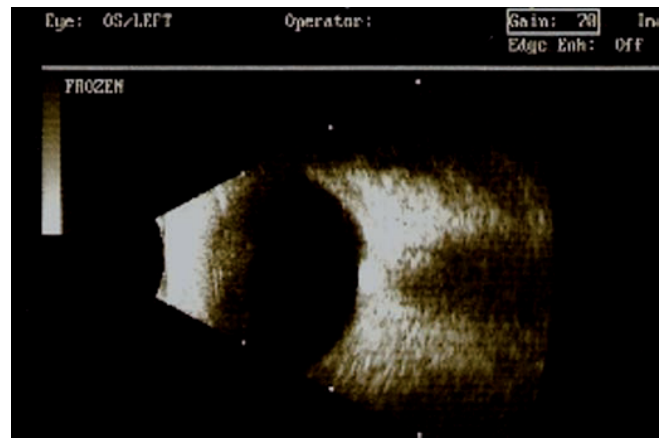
B-scan ultrasound examination of the left eye (patient no. 1). Equivalent hyperechogenic formations – drusen at the level of ONH.
